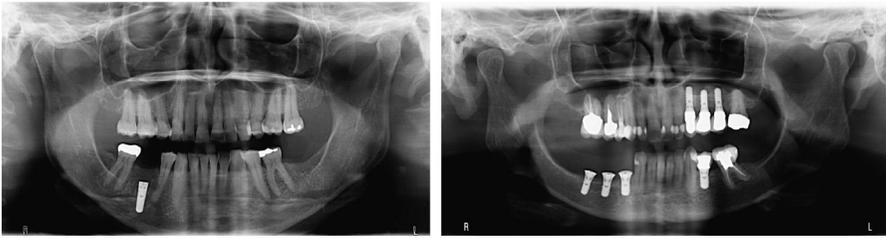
Radiograph showing injury to the inferior alveolar nerve after implant placement. The implant appears to be completely intruding into the inferior alveolar nerve canal.
